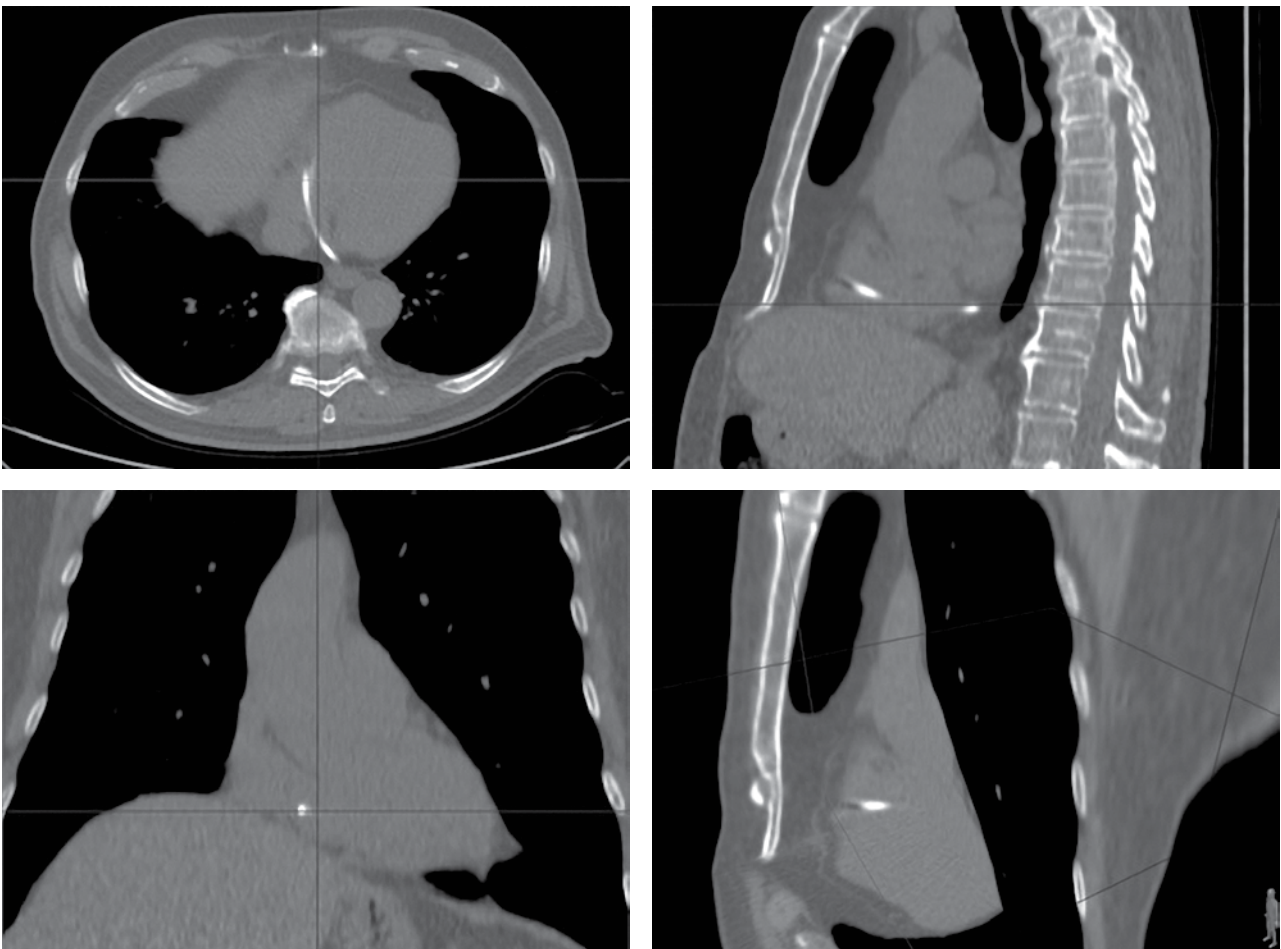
Multi-projection reformatted computed tomography image showing the foreign body in the right atrium.
